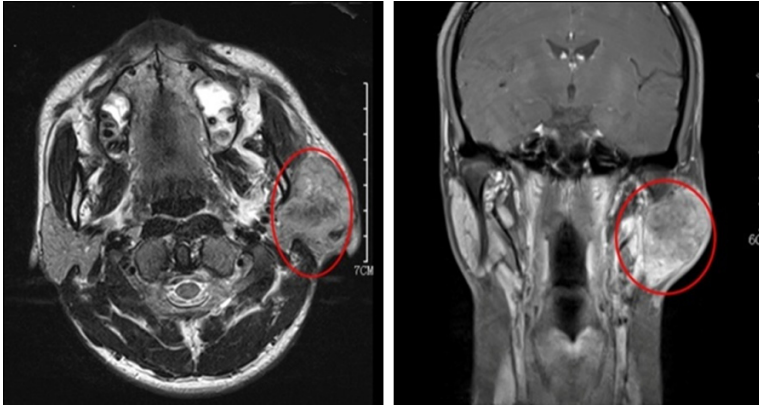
Magnetic Resonance Imaging showed an elliptic lobulated mass on the left parotid gland with clear boundary and uneven signal (oval).
